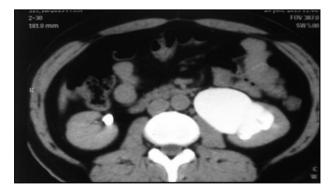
CT image with reconstruction.
